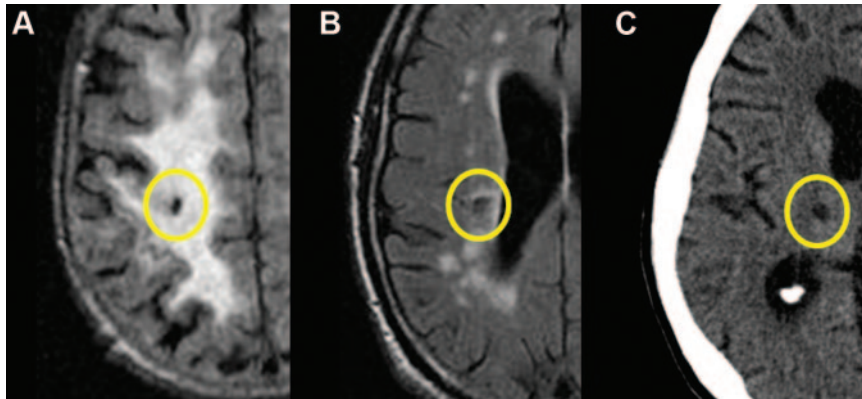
Examples of definite (A) and possible (B) cavities in the centrum semiovale on FLAIR MRI, both with concomitant WML. C, Cavity in the right thalamus on CT.
